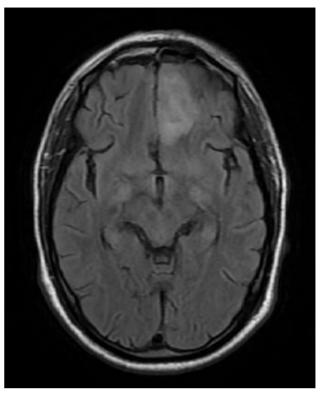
MRI confirming extension into the left frontal lobe forming a 3.6 x 1.7 cm (AP x TRANS) suggesting cerebral abscess.
